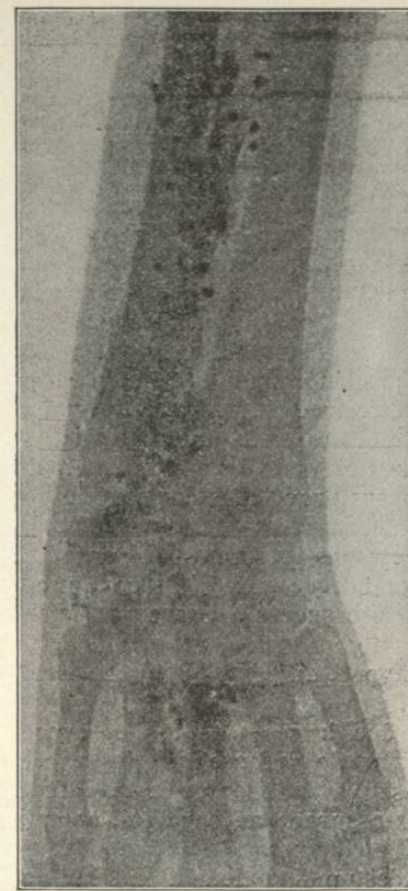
Radiograph. In the case of a marine officer who received a charge of fine shot at close range in the palm of the left hand August, 1900. Wound of exit was on dorsal surface of forearm at junction of lower and middle thirds. During the next four months he had four attacks of lead colic and suffered from plumbism. In December, 1900, the shot was removed. One month later he was free from all symptoms of plumbism. (Nimier.)
